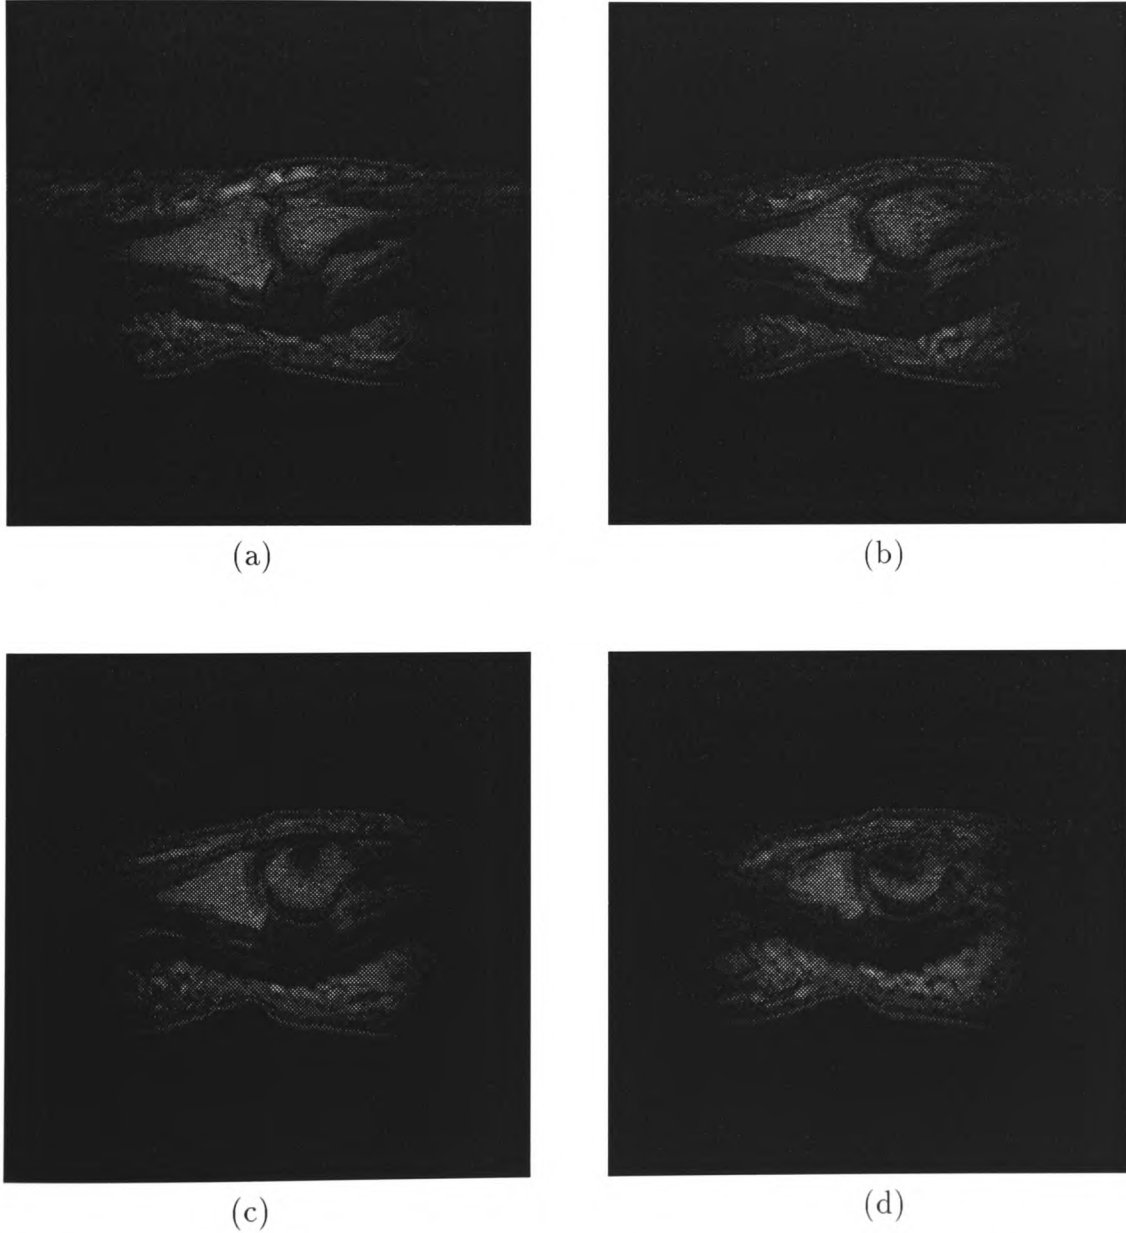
(a) to (d) Subject 1 reference (first occasion T2-weighted) image slices 1 to 4 respectively.
